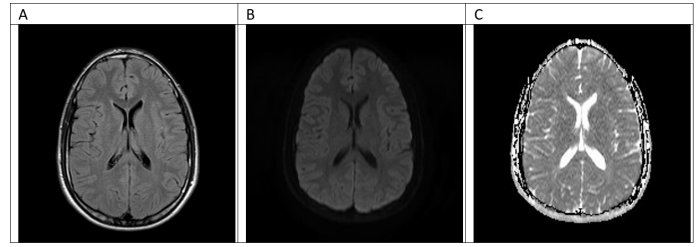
MRI on day 10 after presentation. Axial MRI taken on day 10 after presentation. T2-FLAIR imaging still showed some hyperintensity in the SCC, but also new hyperintense lesions in the basal ganglia and thalamus region (A) (see arrows). Signal intensity at the splenium on DWI is diminished (B), as well as diffusion restriction (C).
